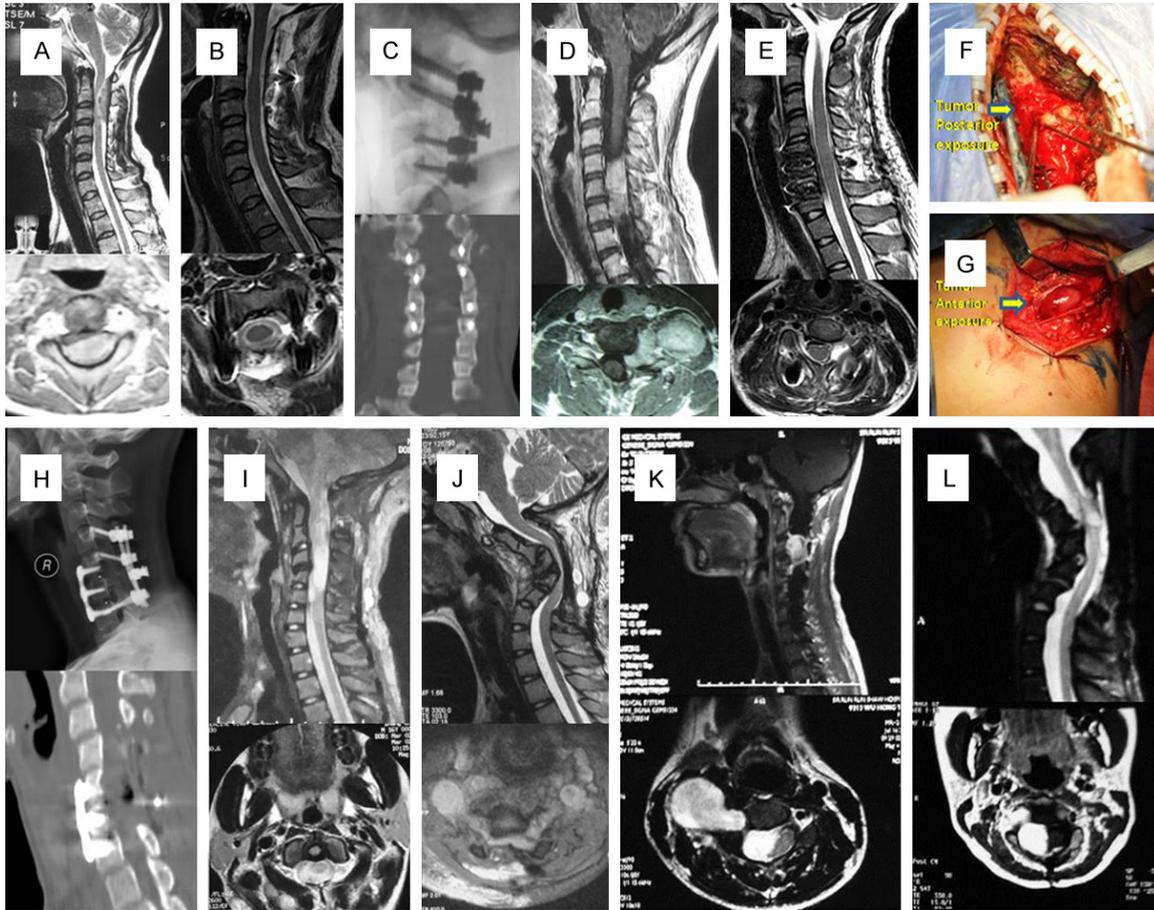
A. Preoperative MRI from case 26 showing an intradural/extramedullary schwannoma of the cervical spine; B. Postoperative MRI showing tumor resection via total laminectomy; C. X-ray cervical spine lateral views showing normal cervical alignment with a lateral mass plate and screws at 28-month follow-up; D. Preoperative MRI from case 41 showing an intra- and extradural/extramedullary (dumbbell-shaped) neurinoma of the cervical spine; E. Postoperative MRI revealing tumor excision via the laminectomy; F. Tumor resection via the posterior procedure; G. Additional anterior approach for resection; H. X-ray and CT images of the cervical spine showing normal cervical alignment with the lateral mass plate, anterior plate and screws at 27-month follow-up; I. Preoperative MRI for case 14; J. The tumor was completely removed, although severe kyphosis occurred 12 months after the operation; K. Preoperative MRI for case 50; L. Incomplete resection and swan-like deformity occurred 12 months after the operation.
